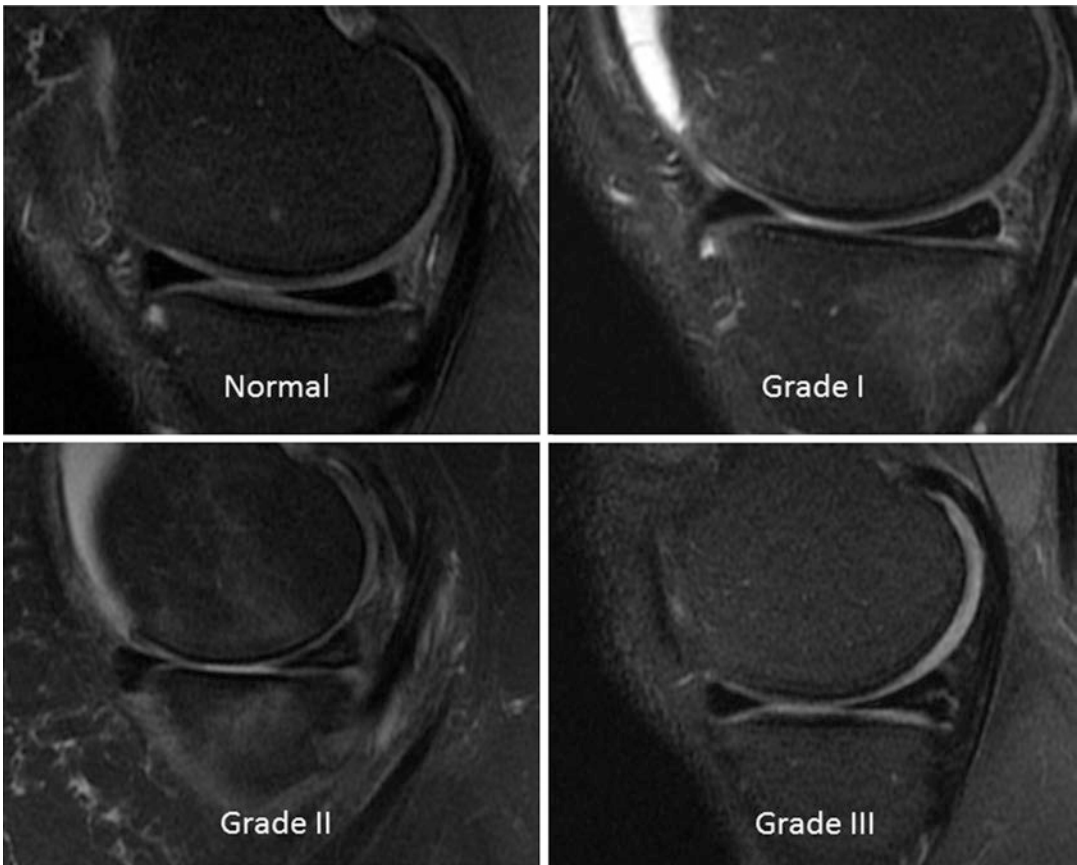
MRI classification of meniscal tears
